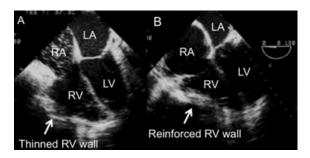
Two-dimensional transesophageal echocardiography four-chamber view of the right ventricular free wall after removal of the pericardial mass (A) and post reinforcement with purse-string sutures (B). A. A thinned free wall can be seen after removal of the pericardial mass. B. The right ventricular free wall can be seen after reinforcement with purse-string sutures. RA = right atrium; LA = left atrium; RV = right ventricle; LV = left vent.
